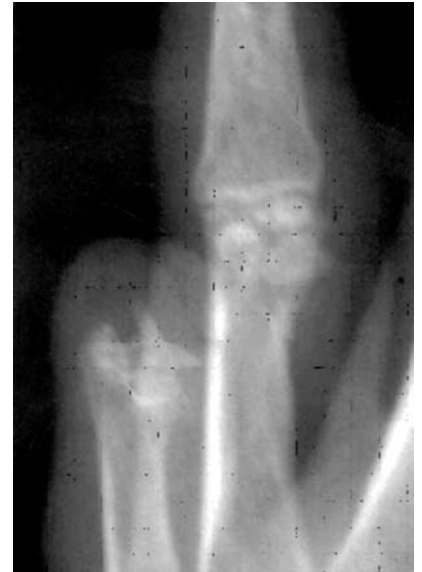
A preoperative X-ray for the same patient showing narrow irregular joint space with old comminuted fracture of the head of PI.
